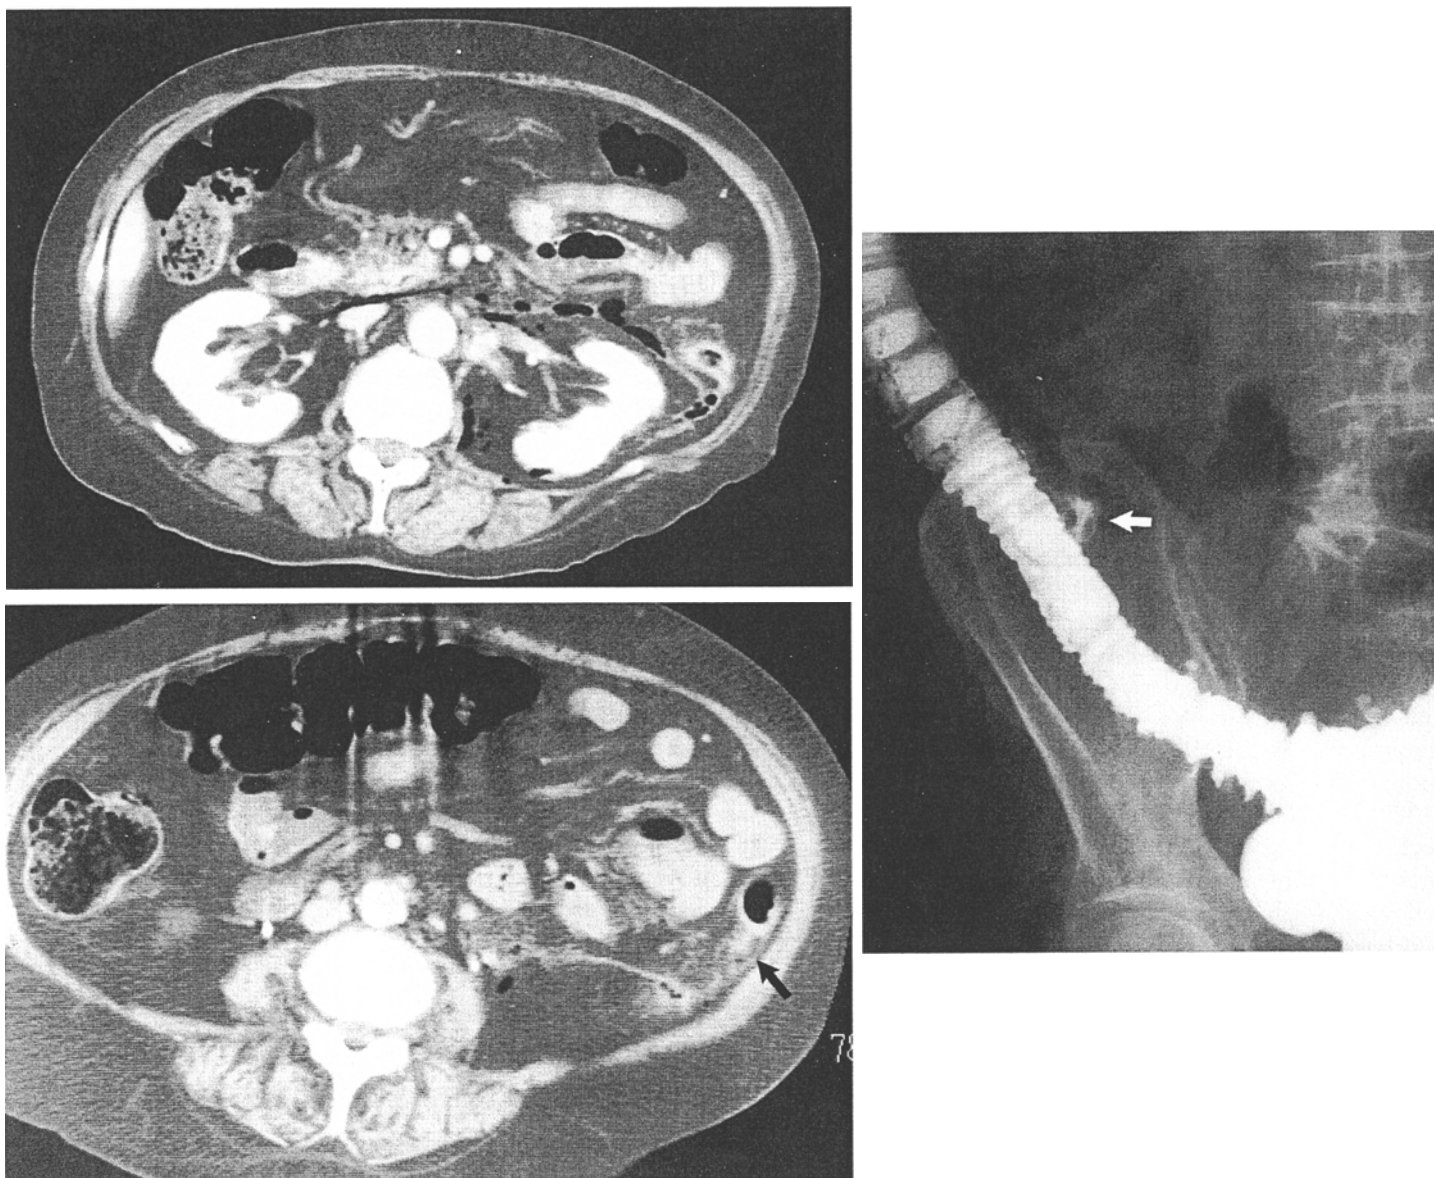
78-year-old woman with perforation of diverticulum of descending colon. Top left, multiple instances of free air present in anterior and posterior pararenal spaces. Bottom left, lower CT image shows a small amount of retroperitoneal air and the dirty fat sign just behind the descending colon (arrow). Right, contrast enema obtained in the prone position shows extravasation of contrast medium from the descending colon (arrow).
